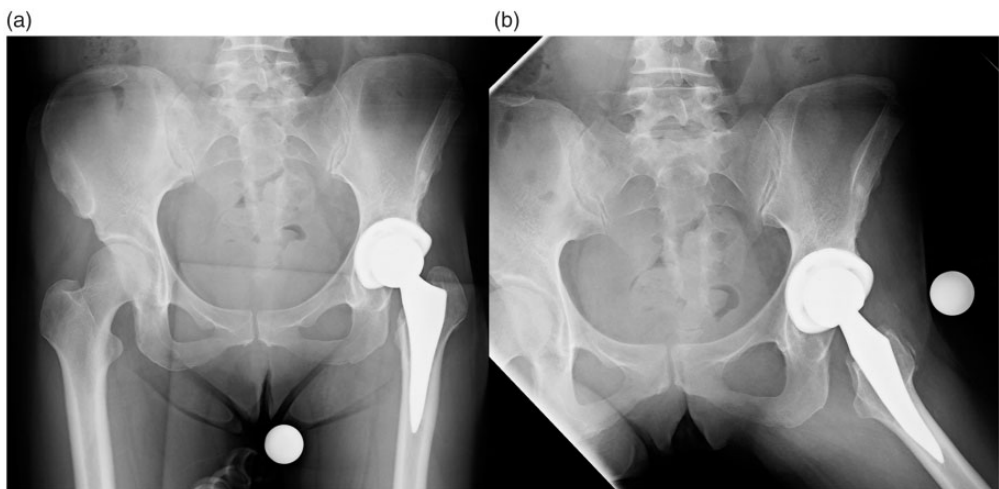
(a, b) Postoperative X-ray of the prosthesis.
